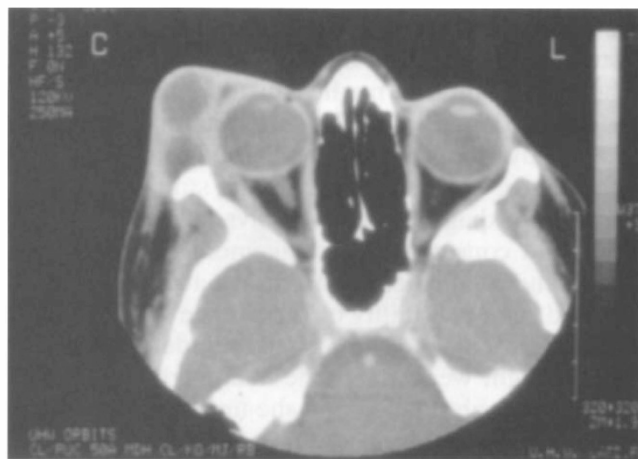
CT scan showing a large soft tissue mass in the lateral wall of the right orbit.
